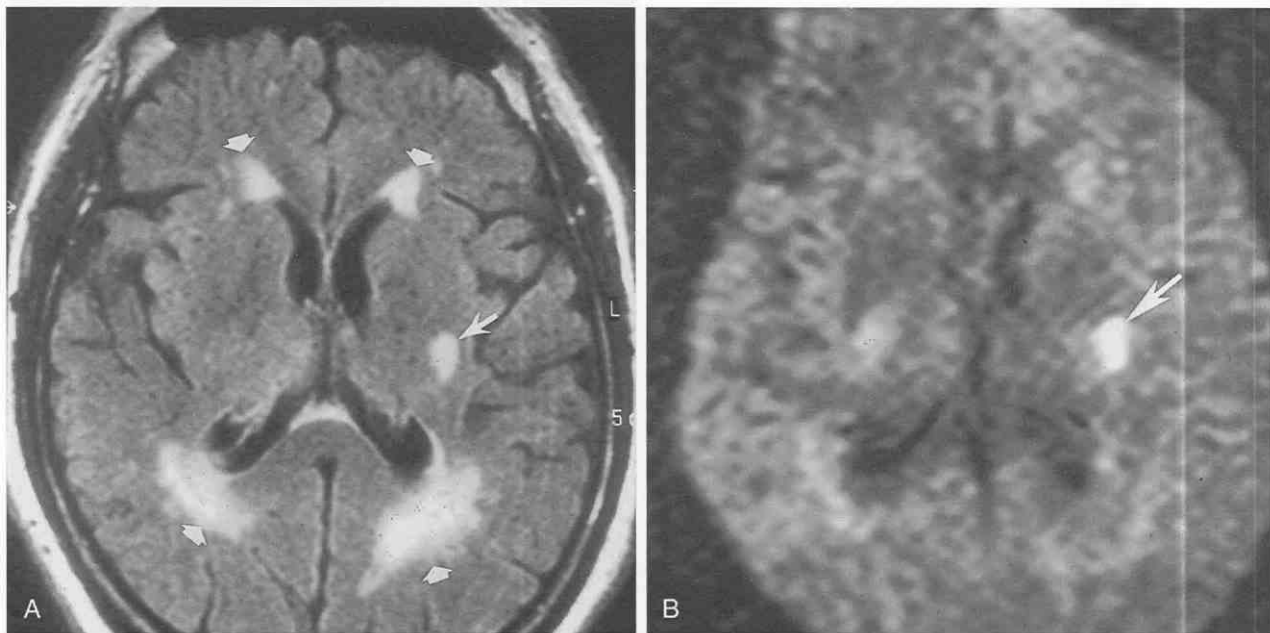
Acute right hemiparesis. *A*, Fluid-attenuated inversion recovery (FLAIR) MR image (TI = 2000) shows high signal in the periventricular regions (*small arrows*) and posterior limb of the left internal capsule (*arrow*). *B*, Axial diffusion-weighted image (b = 980) shows increased signal only in the left internal capsule, consistent with acute stroke (*arrow*). Other areas that were hyperintense on the FLAIR image presumably represent older ischemic changes.
